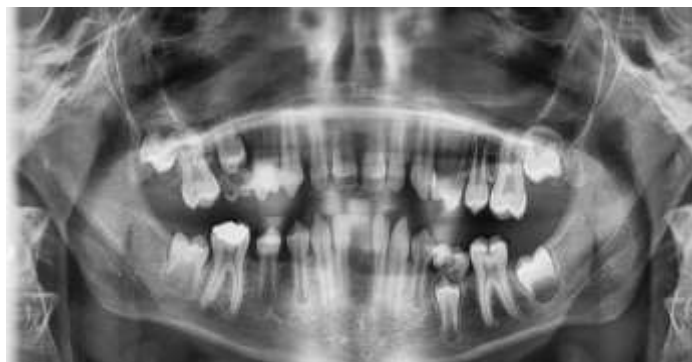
Radiographic image taken after treatment in a 13-year-old patient
